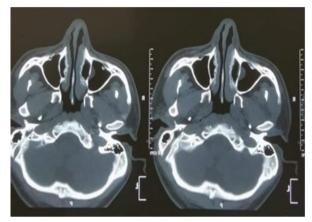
CT scan of 30 years old male patient shows a slight deviation of the nasal septum.
